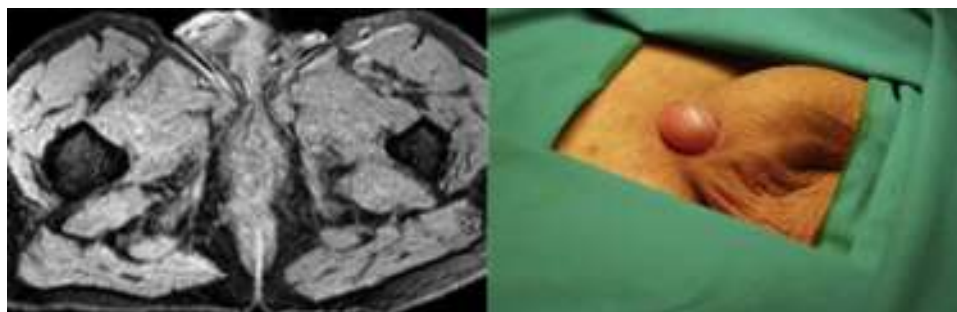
Magnetic resonance image of the well-circumscribed mass and Surgical resection of the mass.
